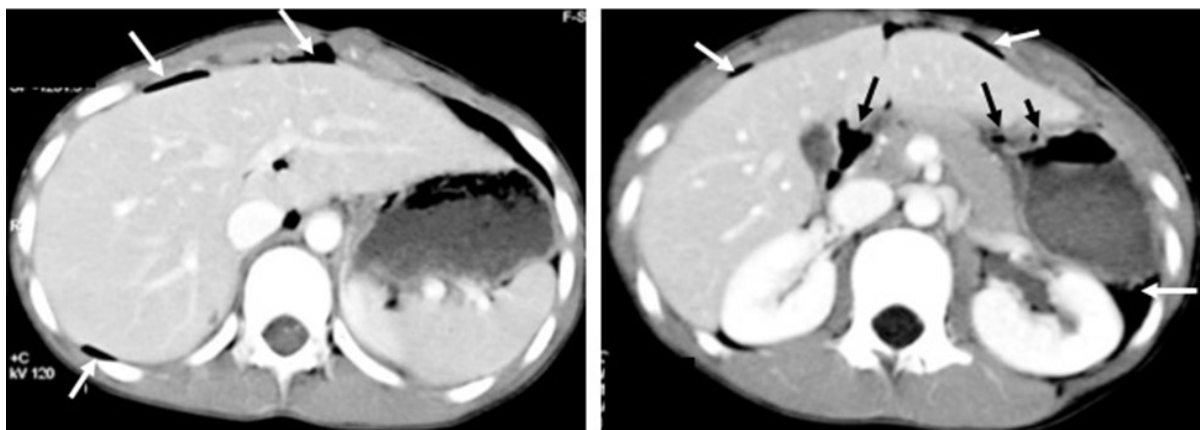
Contrast-enhanced CT scan of abdomen in axial plane soft tissue window at the level of stomach region showing multiple foci of free air (white and black arrows) seen surrounding the liver, the stomach and at porta hepatis region.
